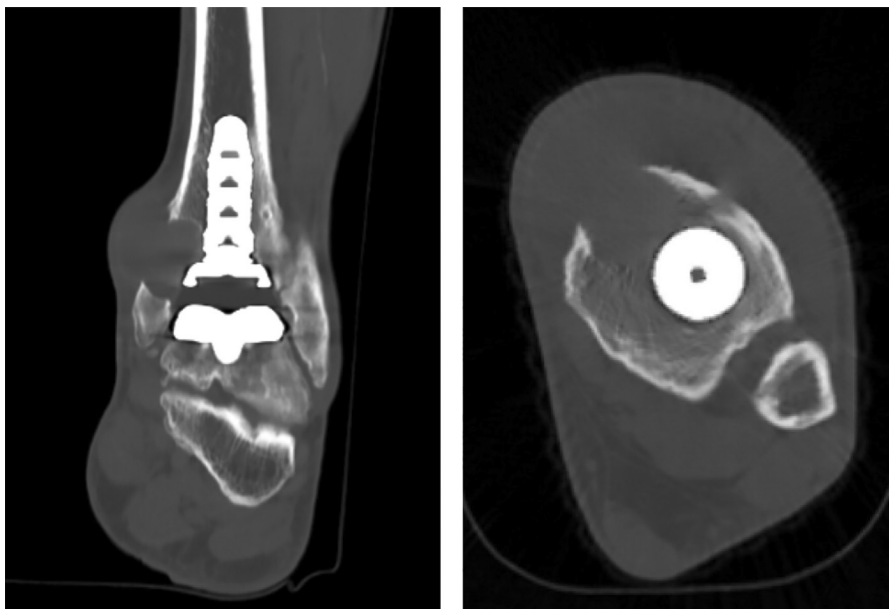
Coronal and axial CT images representing a ballooning periprosthetic bone cyst of the medial malleolus that was evident on physical examination 5 years after TAA.
